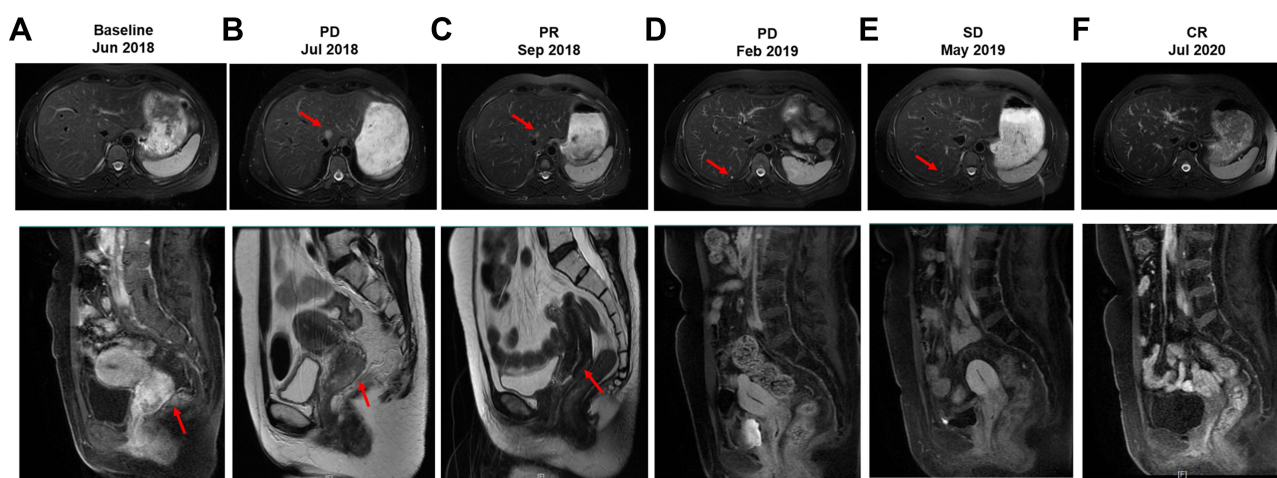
Magnetic resonance imaging (MRI) of the liver (upper) and cervical (lower) lesions at treatment milestones. (A) at baseline; (B) two weeks after IMRT directed to pelvis; (C) two months after IMRT directed to neck combined with brachytherapy and platinum-based chemotherapy (PR); (D) seven months after IMRT directed to neck combined with brachytherapy and platinum-based chemotherapy (PD). (E) three months after pyrotinib treatment (SD); (F) seventeen months after pyrotinib treatment (CR). The red arrows in upper and lower panels indicated metastatic liver lesion and the primary cervical adenocarcinoma, respectively.
